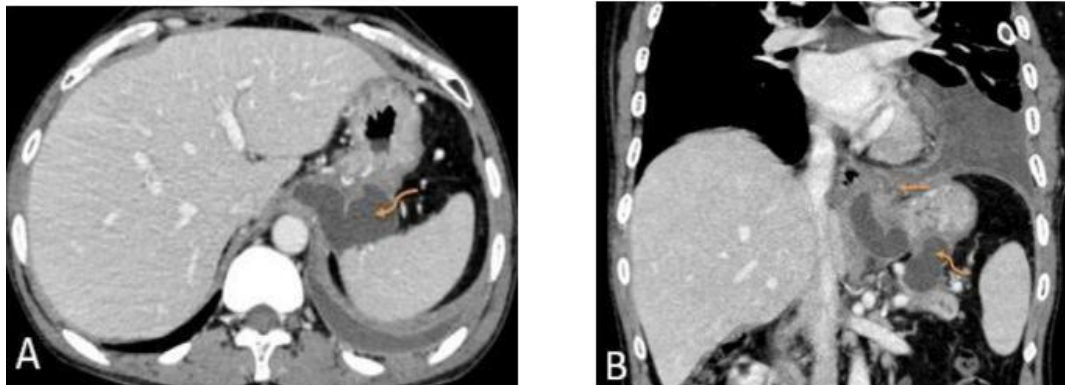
Contrast-enhanced CT images (A – axial, B – coronal) demonstrating a peripherally enhancing walled-off necrotic collection in the pancreatic tail region with a slender fistulous tract extending superiorly across the diaphragm into the left pleural cavity, associated with moderate left-sided pleural effusion—features consistent with pancreatico-pleural fistula.
